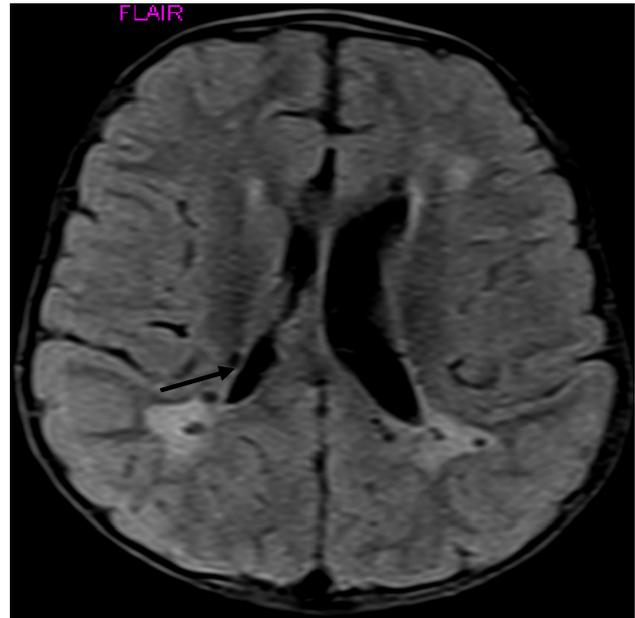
Axial FLAIR Image Shows Periventricular Hyper Intensities with Multiple Hypo Intense Cystic Lesions
